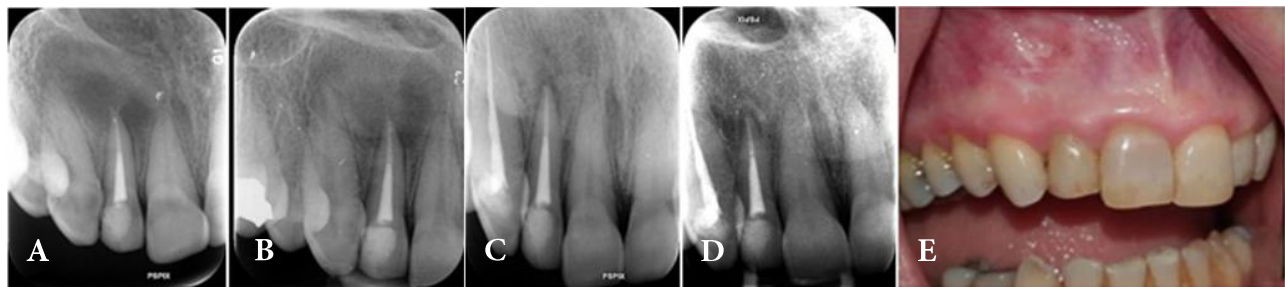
Follow up radiograph with A) 3-, B) 6-, C) 12- and D) 36-months period revealing gradual osseous repair of the defect; D) A small remaining periapical radiolucency, suggests scar tissue formation; E) 3-year follow up photograph, healing of the soft tissue is observed with scar tissue formation at the site of cavity opening
